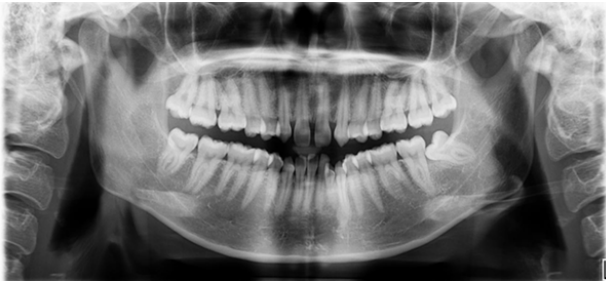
Case 3: Pre-treatment DPT showing radiopacity present at periapical area of LL5
